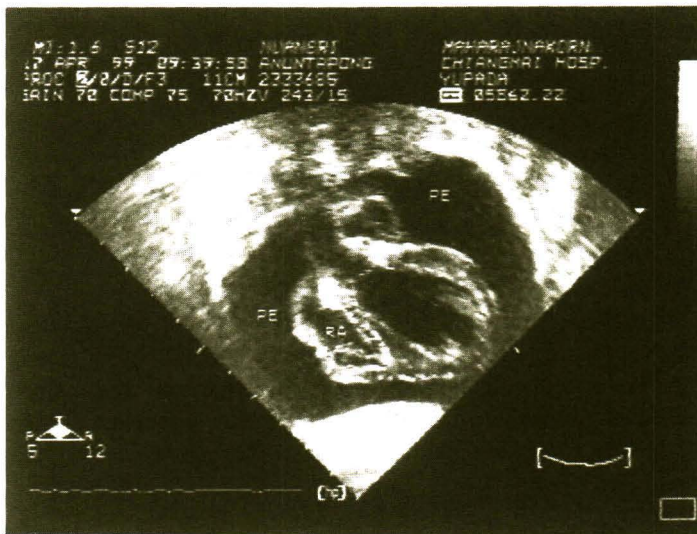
Echocardiogram in subcostal view shows massive pericardial effusion. PE = pericardial effusion, RA = right atrium, S = superior, I = inferior, R = right, L = left.
